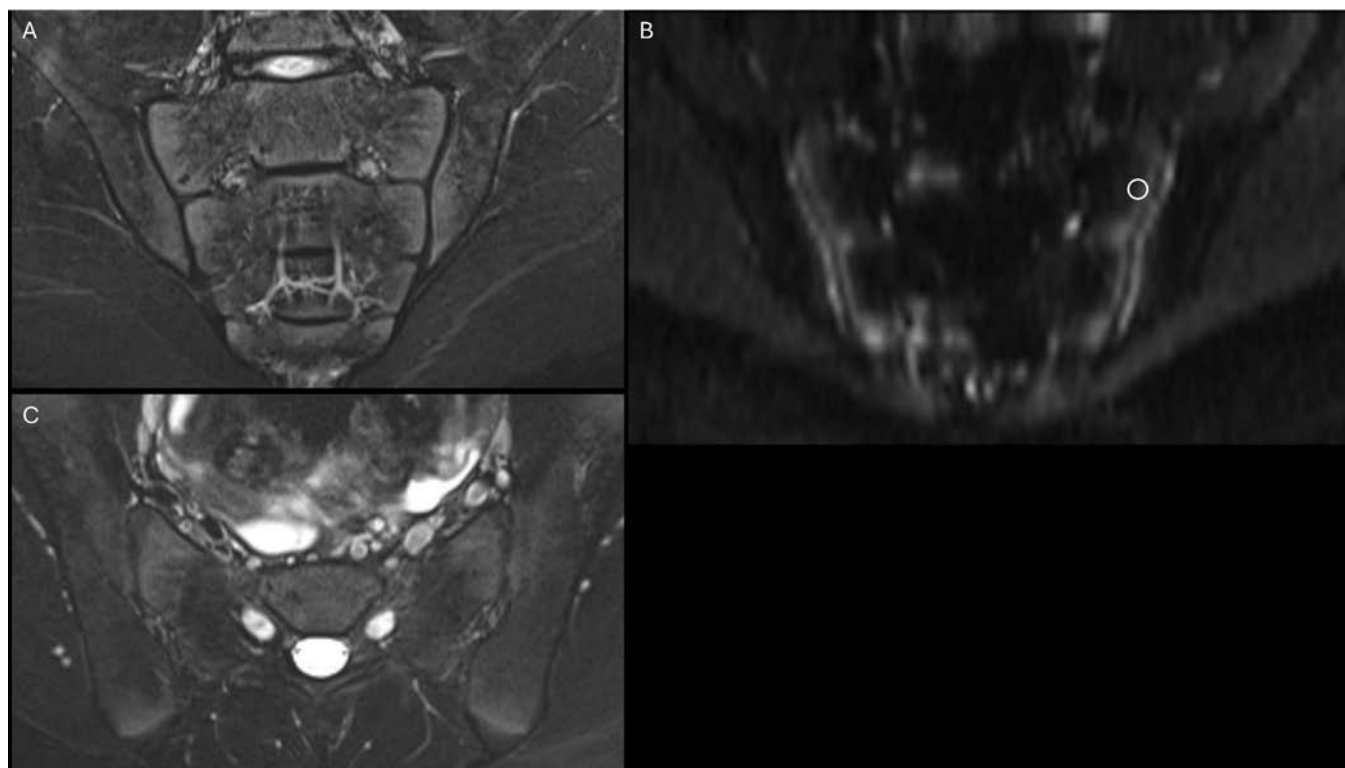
Representative application of the DWI technique. (A) Coronal oblique STIR showing normal type I maturational signal. (B) Coronal oblique DWI showing ROI placement in the superior left sacrum. Measured ADC was $666 \text{ mm}^2/\text{s}$. (C) Axial oblique T2 fat-saturated image showing normal maturational signal in the iliac and sacral bones about the SIJs and iliac apophyses. ADC, apparent diffusion coefficient; DWI, diffusion-weighted imaging; ROI, region of interest; SIJ, sacroiliac joint.
